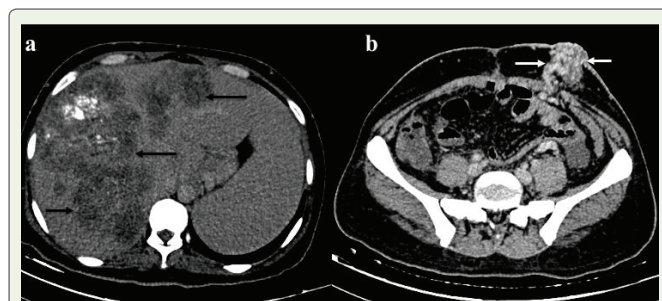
Axial contrast enhanced computed tomography (CECT) venous phase images. (a) showing multiple well-defined hypodense lesions (black arrows) in both the lobes of liver. There are few foci of calcifications are seen in these lesions likely secondary to the chemotherapy. (b) lower abdomen axial section image showing multiple tortuous vessels (white arrows) around the stoma suggestive of peri-stomal varices.
